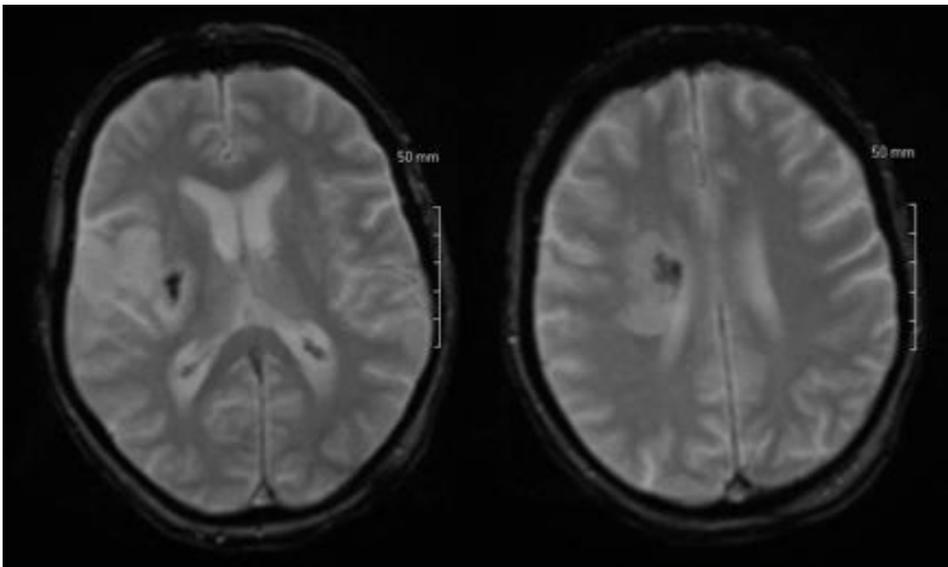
MRI brain (Gradient echo images) showed acute hemorrhages (deoxyhemoglobin) within the right lentiform nucleus and corona radiata.
